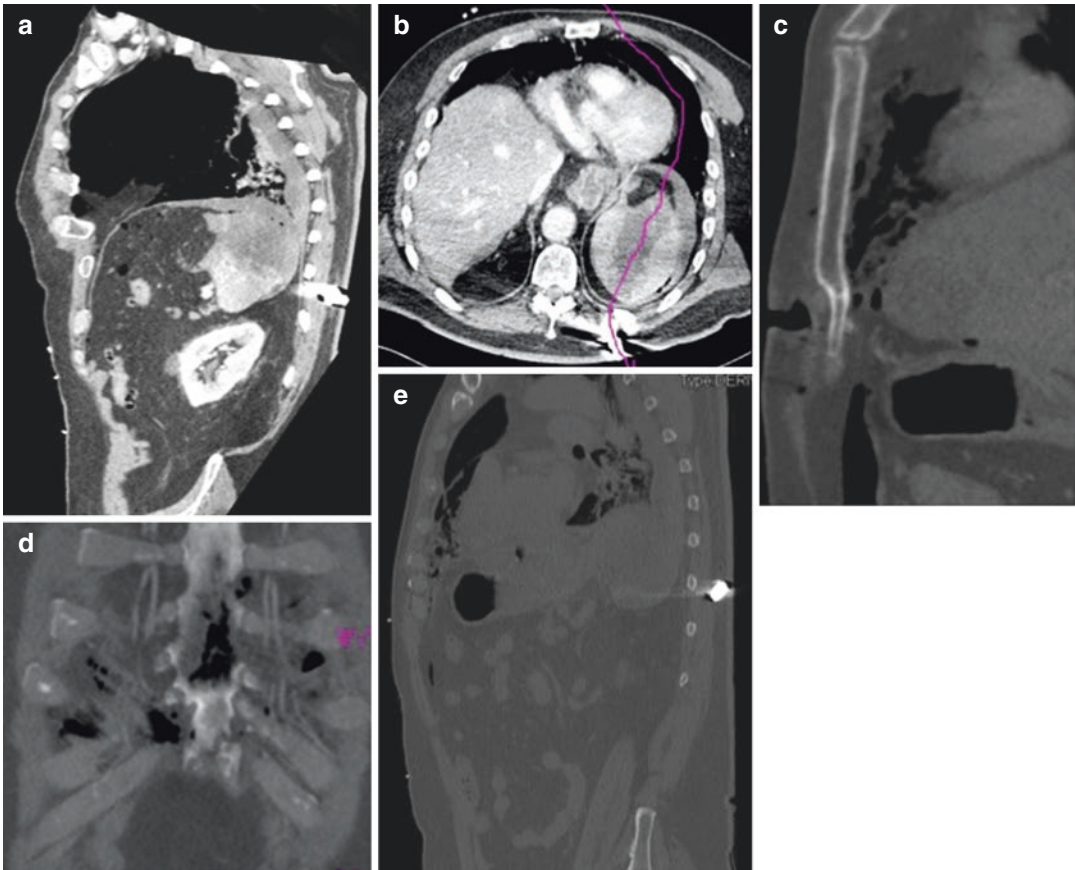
CT trajectory. CT allows to depict the trajectory using multiple window levels and multiplanar reconstruction (a–e). If the trajectory is not linear, as often occurs due to the different densities of crossed tissues, curved reconstruction along the bullet pathway (a, b)
